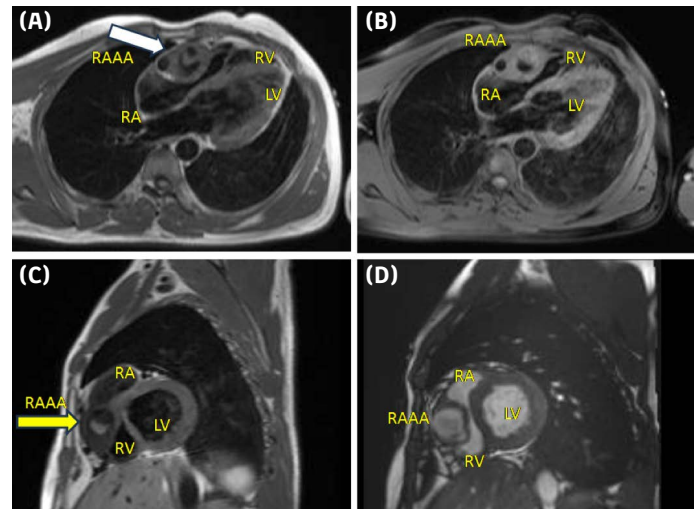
(A-D) Cardiac magnetic resonance images obtained from different segments show a thrombus embedded in the tissue of the right atrial appendage (white and yellow arrows).
